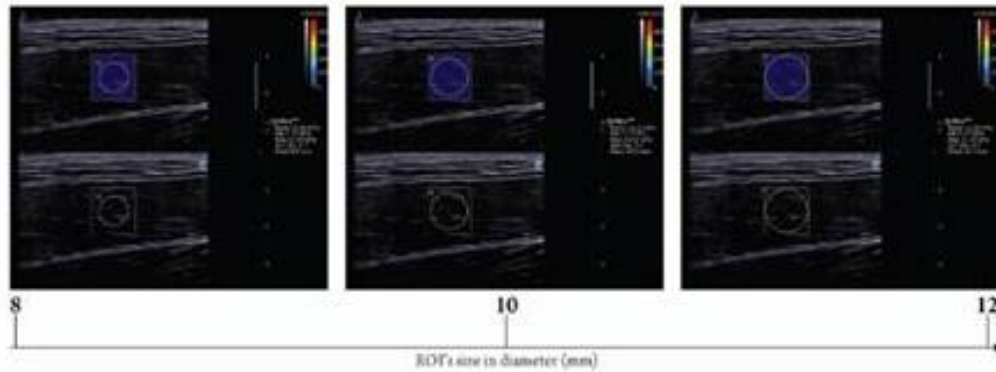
Longitudinal sonograms of rectus femoris (RF) with elastic modulus measured by various region of interest (ROI) sizes. Upper images show color-coded box presentations of RF elasticity (stiffer areas were coded in red and softer areas in blue) superimposed on a longitudinal grey scale sonogram of RF, with the circle representing the region of interest and its corresponding elastic modulus demonstrating under Q-Box™ on the right. Bottom images show longitudinal grey scale sonograms of RF on the identical scan planes. Transducer pressure applied was light for 8 to 12 seconds during the acquisition of the SWUE sonogram. doi:10.1371/journal.pone.0044048.g003
